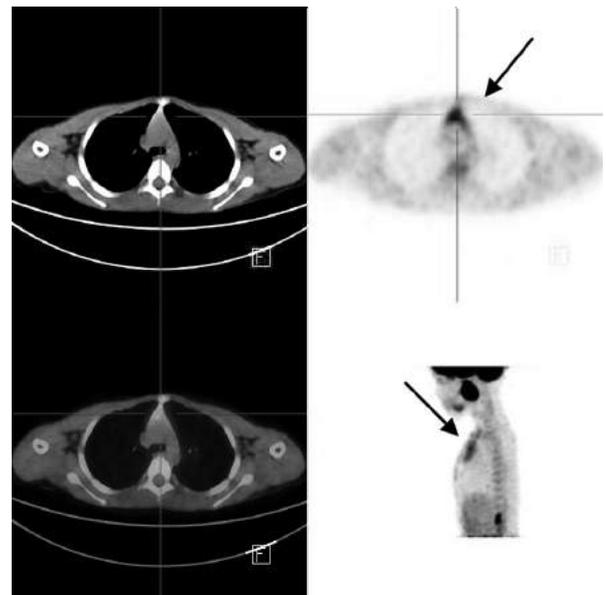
Physiologic intense FDG activity in thymus in a 7-year old patient (arrows on PET, transversal image and MIP sagittal image)
